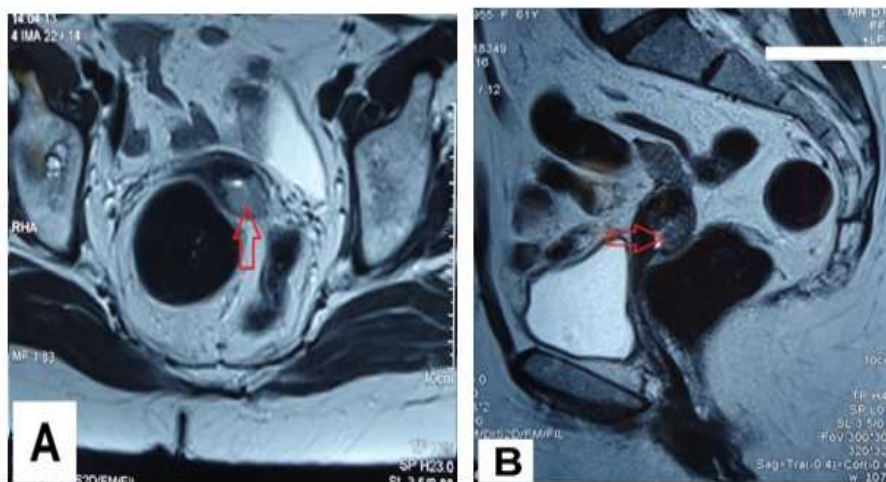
Pelvic MRI. (A) Axial view and (B) sagittal view showing a tumor mass of the cervix (Red arrows).
